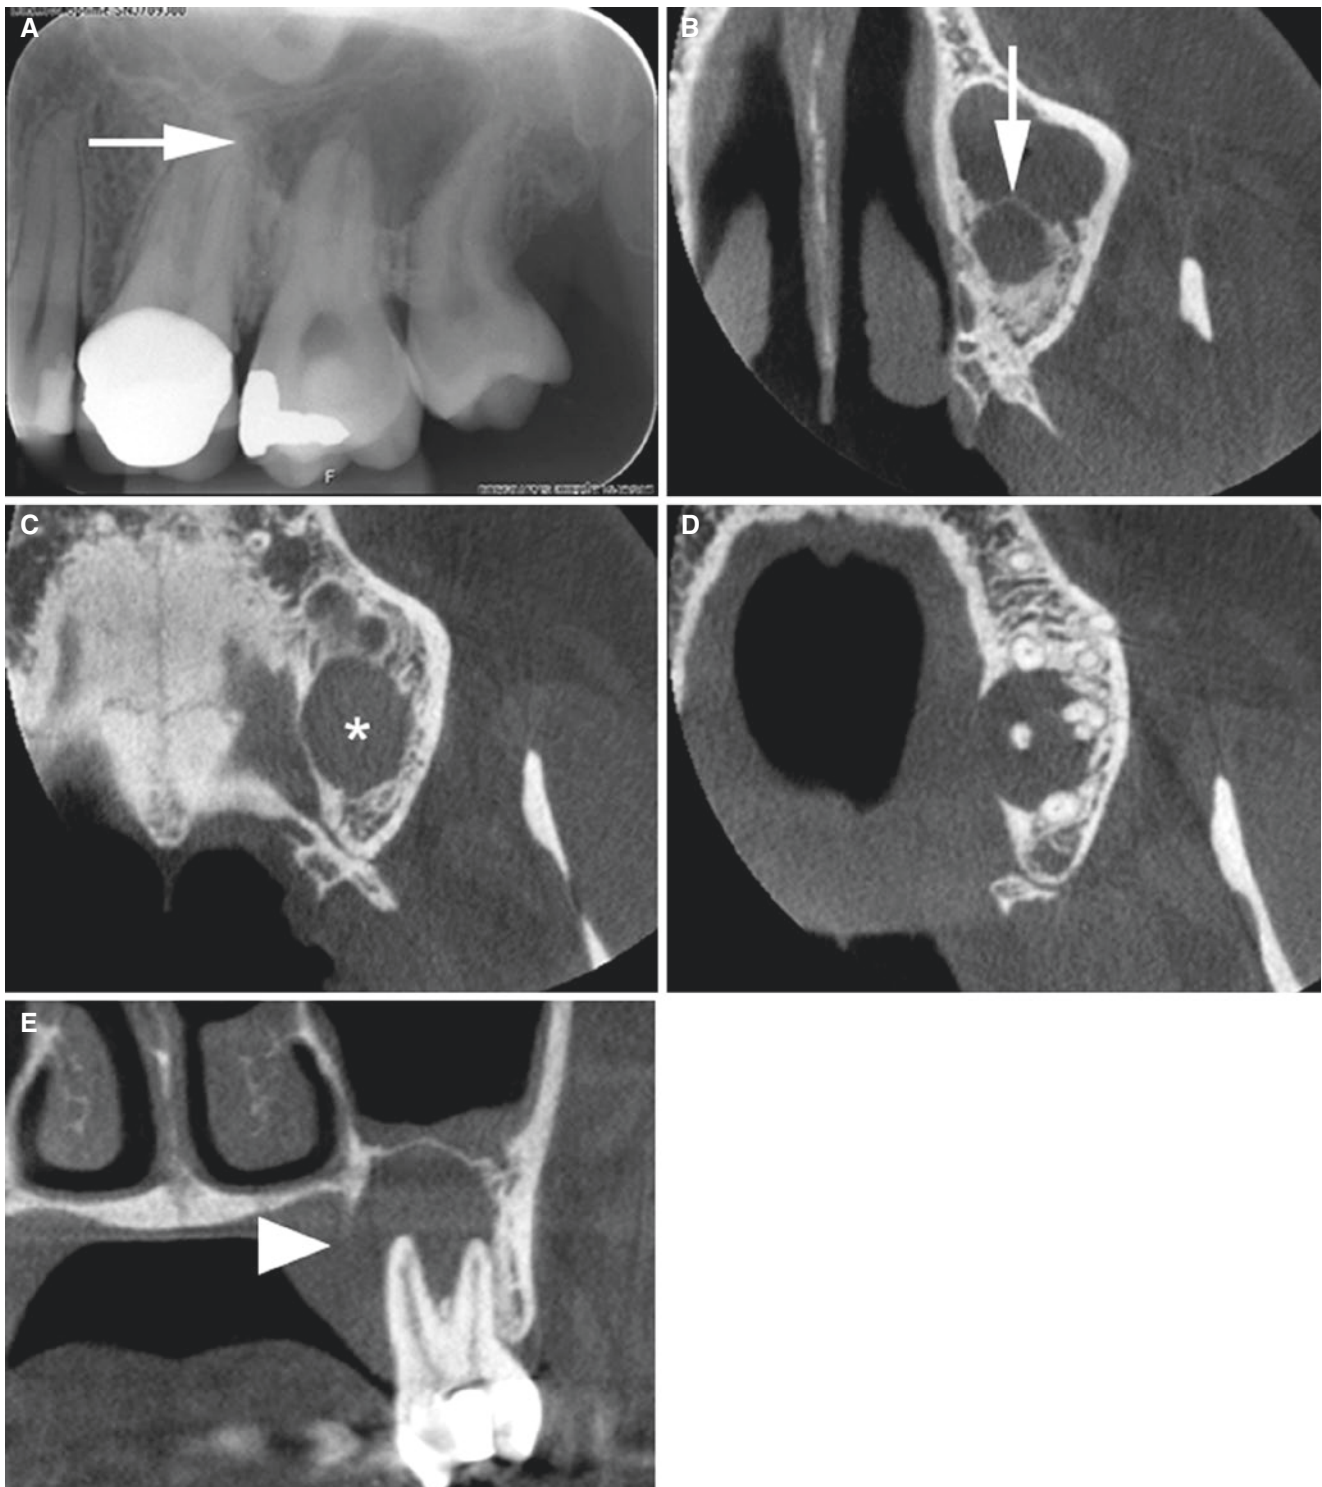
Radicular/periapical cyst, maxilla; 32-year-old female with some discomfort and swelling with fistula in the left maxilla. (A) Intraoral view shows periapical radiolucency at the second molar
